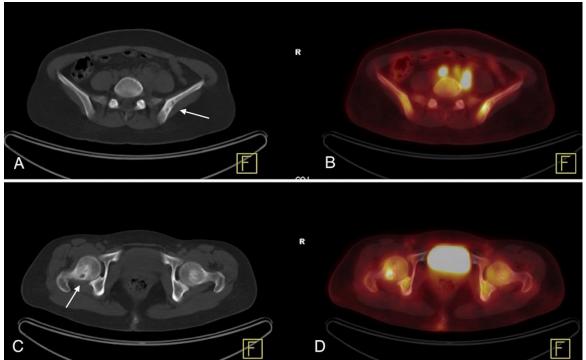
CT (A, C) and PET/CT fusion (B, D) images revealed FDG avid lytic lesions in the left iliac bone and right femur head, respectively
